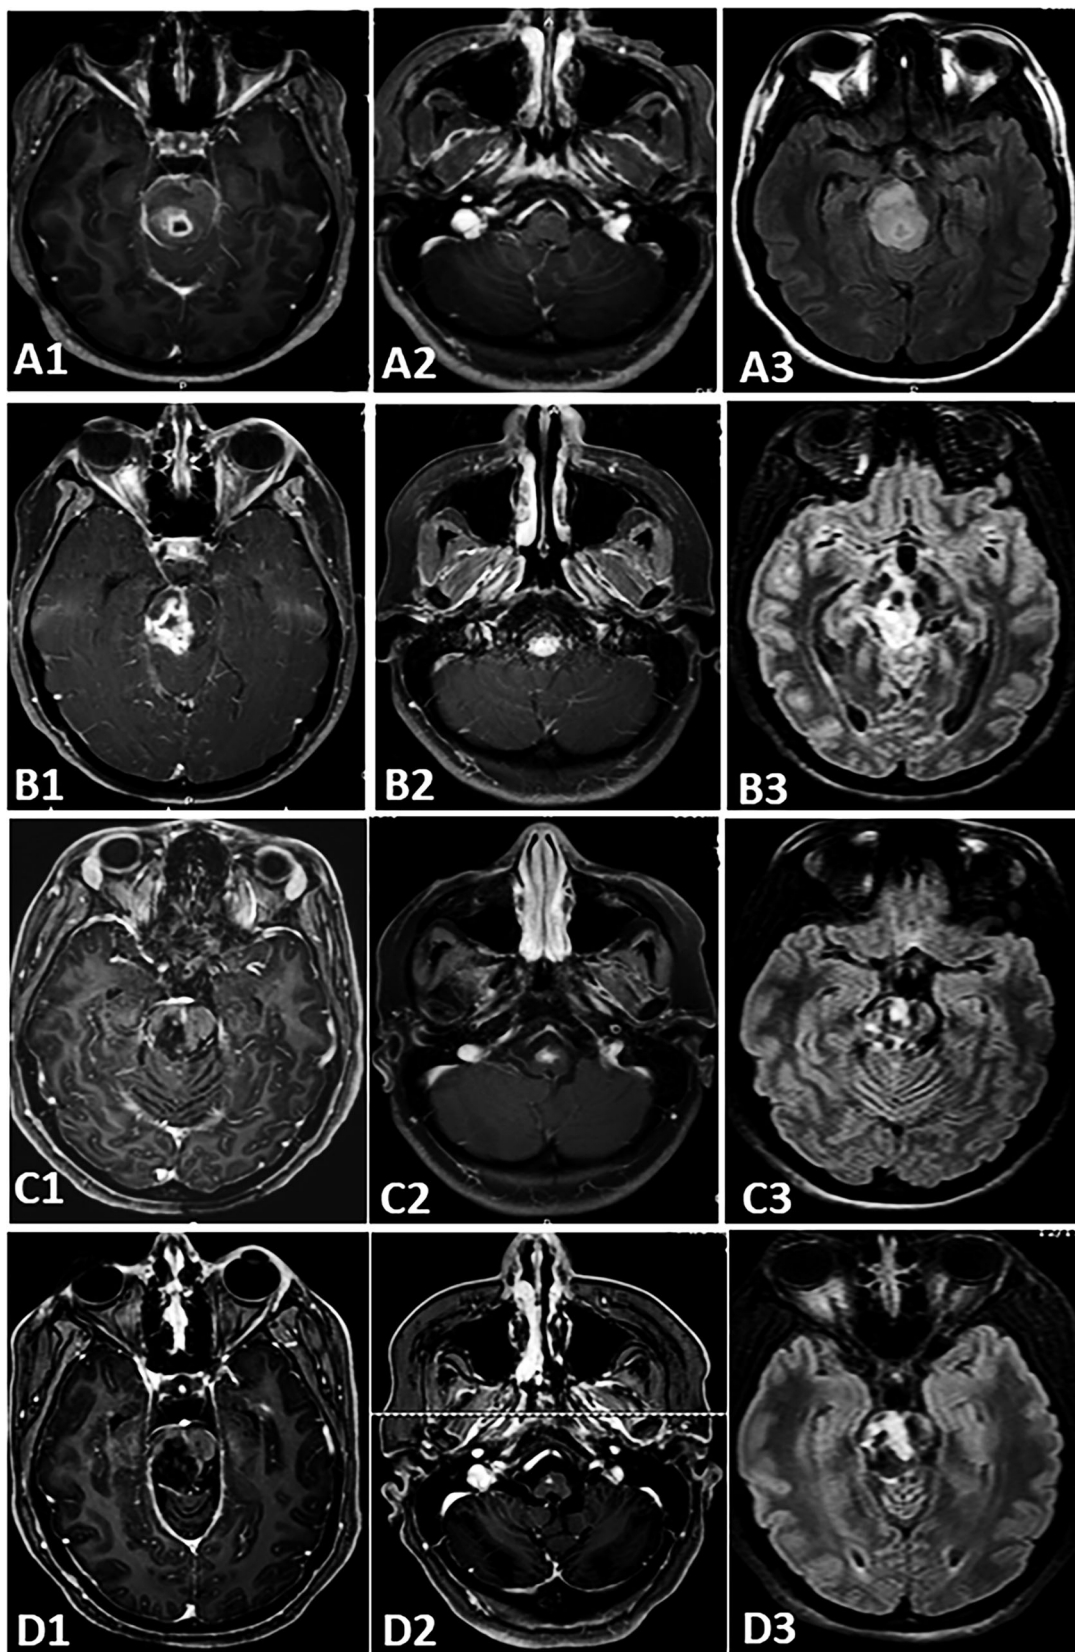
MRI Brain – Disease evolution over time. A1–3: 10/3/2014: Post-contrast and FLAIR MRI axial sequences when the patient was first diagnosed, revealing a midbrain lesion (A1) and no disease in the medulla (A2) with significant FLAIR effect (A3). B1–3 10/29/2015: Imaging when patient first established care with us, prior to everolimus treatment, with enhancing disease in the midbrain (B1) now extending down to medulla (B2) with associated FLAIR signal (B3). C1–3 9/25/2017: Over a year after treatment onset, there is notable improvement in the lesion in the midbrain (C1) and the medullary extension is smaller (C2). D1–3 12/15/2020: Most recent MRI demonstrates a continued lack of enhancement in the midbrain (D1) and a residual speck of enhancement lower down (D1) with evolving FLAIR signal.
